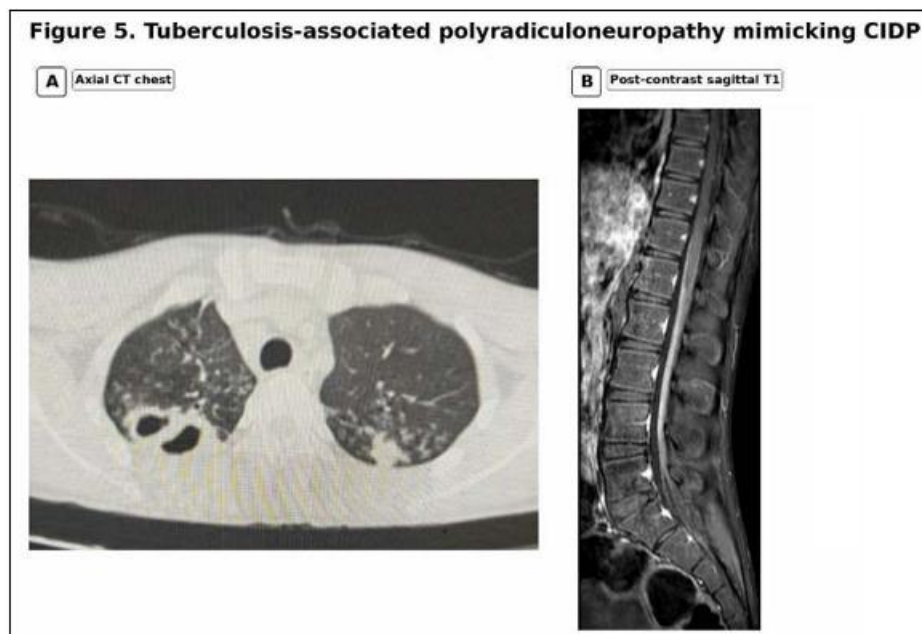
Tuberculosis-associated polyradiculoneuropathy mimicking CIDP. Axial CT chest demonstrates upper-lobe predominant cavitary pulmonary disease with surrounding centrilobular/tree-in-bud-type nodularity. Post-contrast sagittal lumbosacral MRI demonstrates enhancement along the cauda equina/root region. The clinical phenotype was a painful progressive areflexic sensorimotor polyradiculoneuropathy with albuminocytological dissociation.
